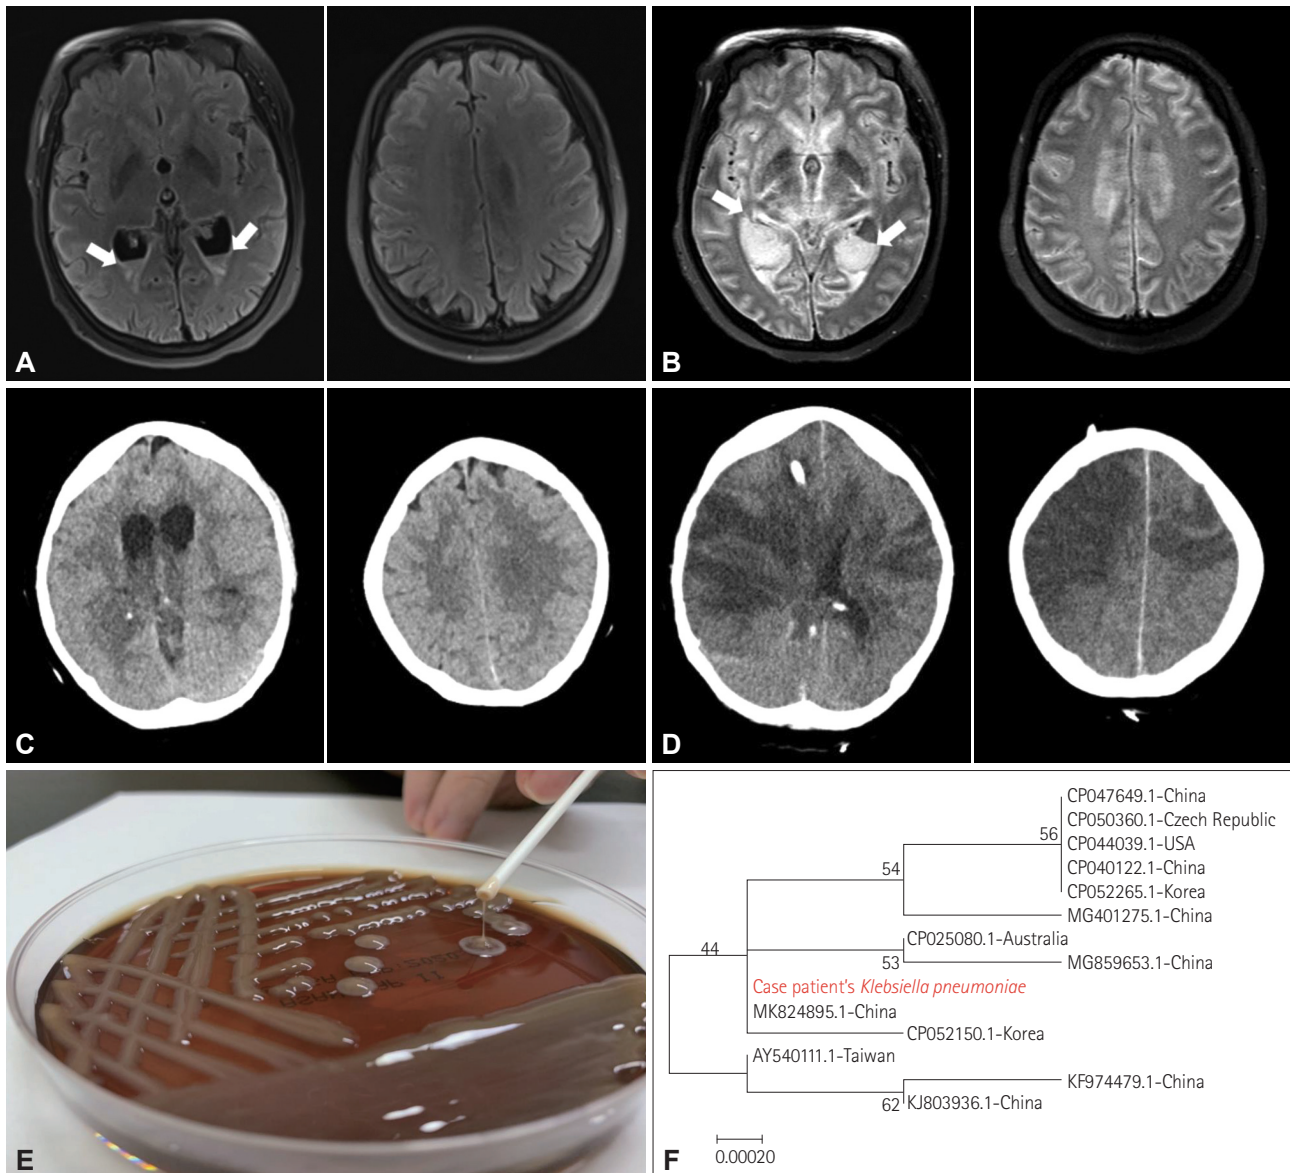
Brain MRI, string test, and phylogenetic tree of the patient with hvKp. A: Initial brain FLAIR MRI images showed subtle increased signals throughout the cortices in both cerebral hemispheres and the presence of a fluid-fluid level in both lateral ventricles (arrows), suggesting diffuse meningoencephalitis. B: On hospital day 2, follow-up FLAIR MRI images showed interval progression in diffuse increased signals throughout the cortices in both cerebral hemispheres and an increased amount of fluid in the lateral ventricles (arrows). C: On hospital day 3, brain CT images showed diffuse brain swelling and hydrocephalus. D: On hospital day 12, brain CT images showed cerebral infarctions in both hemispheres caused by progression of cerebral edema. E: The string test in an isolated colony of *Klebsiella pneumoniae* from the patient on an agar plate, which showed hypermucoviscosity with a 5-mm-long viscous filament. F: Phylogenetic tree of isolates from blood and cerebrospinal fluid of the patient with hvKp K1 based on 16S rRNA gene sequences. The tree was reconstructed using the neighbor-joining method with MEGA software (version 6). Scale bar indicates the nucleotide substitutions per site. CT: computed tomography, FLAIR: fluid-attenuated inversion recovery, hvKp: hypervirulent *Klebsiella pneumoniae*, MRI: magnetic resonance imaging.
